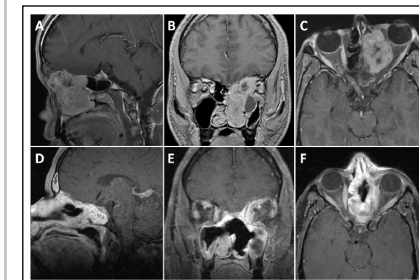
A-C: Preoperative sagittal (A), coronal (B), and axial (C) T1-weighted Gd-enhanced MRI demonstrating an adenoid cystic carcinoma invading the cribriform plate and left lamina papyracea that was resected using an endoscopic endonasal transcribriform approach with subsequent repair using the triplelayer reconstruction technique. D-F: Postoperative sagittal (D), coronal (E), and axial (F) T1-weighted Gd-enhanced MRI at 3 months after surgery demonstrating vivid enhancement of the nasoseptal flap at the ventral skull base with restoration of previous proptosis.
